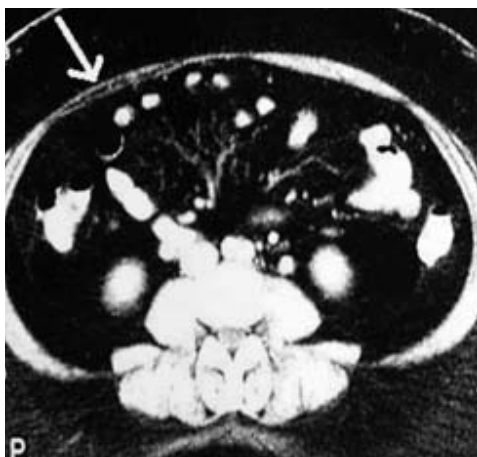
Abdominal computed tomographic scan showing a defect in the abdominal wall in the right upper quadrant (arrow). In this patient, omentum had become incarcerated in a ventral hernia inferior to an old cholecystectomy scar.
